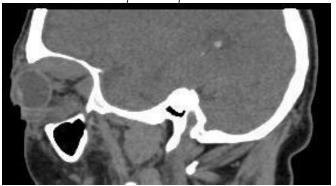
CT of the orbits: B- sagittal image. Pathology of the extraocular muscles with pronounced thickening of the rectus muscles and superior oblique muscle.
